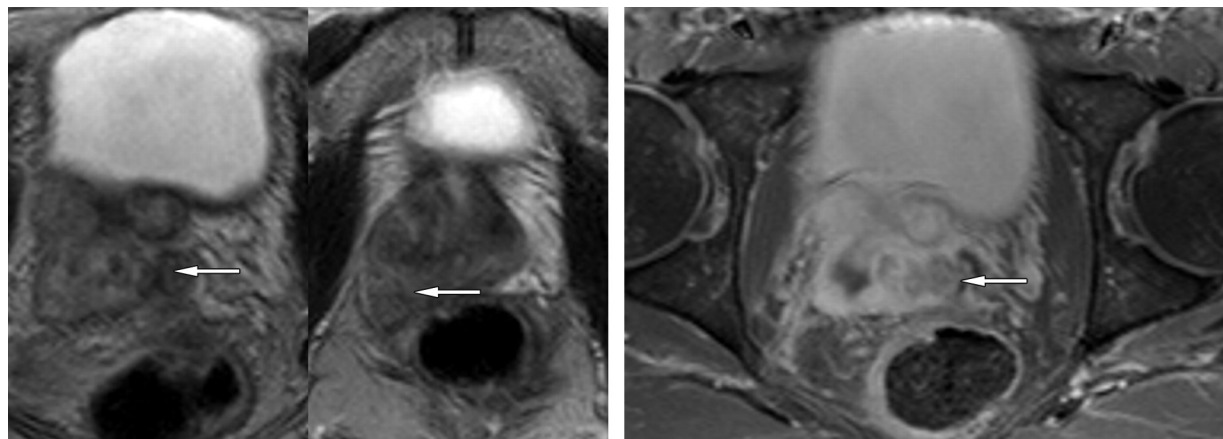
Leiomyosarcoma of the prostate in a 45-year-old man. (a) Two axial sequential T2-weighted MR images (image at left obtained more cephalad than image at right) show a large lobulated heterogeneous mass (arrows) arising from the right midportion of the gland and extending to the base. (b) Axial contrast-enhanced MR image of the tumor shows avid and heterogeneous enhancement with areas of central necrosis (arrow). The patient underwent radical prostatectomy and partial cystectomy, as well as radiation therapy.
